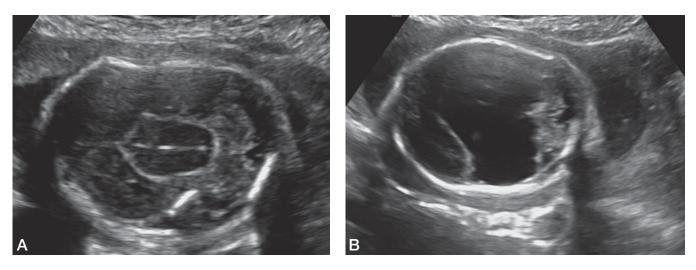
Prenatal sonographic image at 23 weeks from fetus with alobar holoprosencephaly. A. Axial view with fused thalami. B. Single communicating ventricle.
